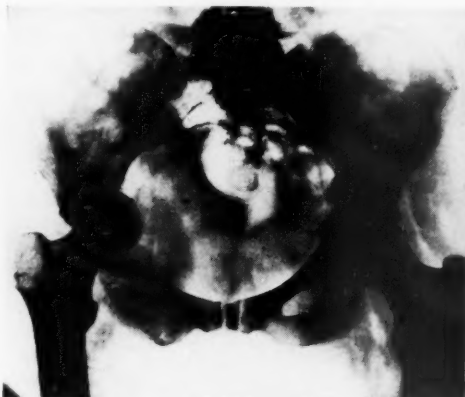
Case 1: Roentgenogram of pelvis, showing the outline of a neoplastic mass in relation to the right acetabulum, invasion of the adjacent bone, and central dislocation of the hip.
